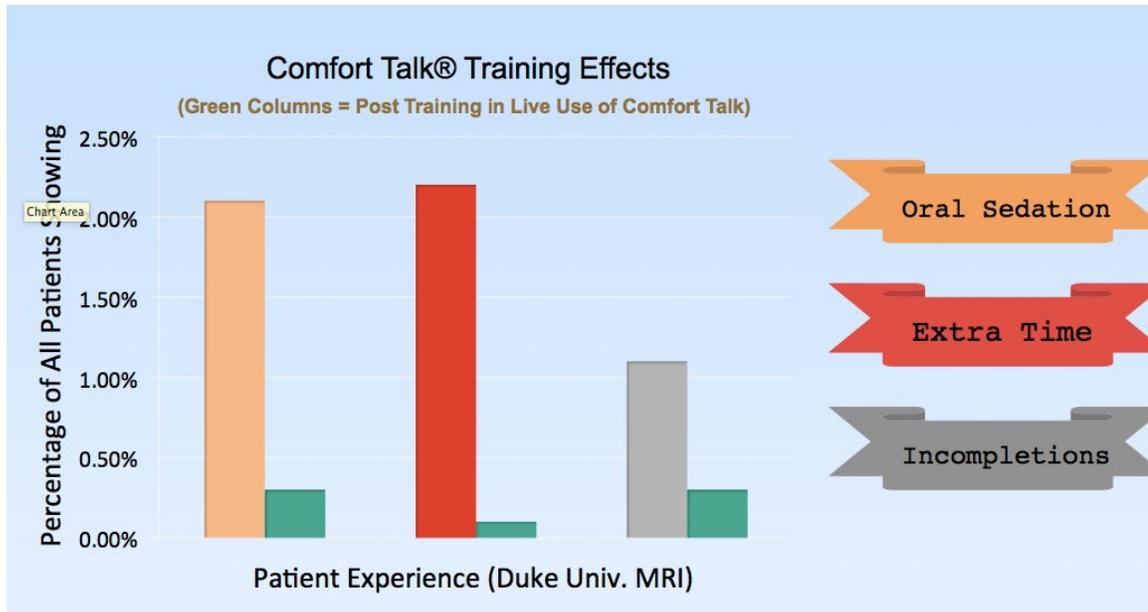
Data obtained at Duke Medical Center MRI before and after Comfort Talk training enabling personnel to deliver verbiage integrated in the Comfort Talk app
